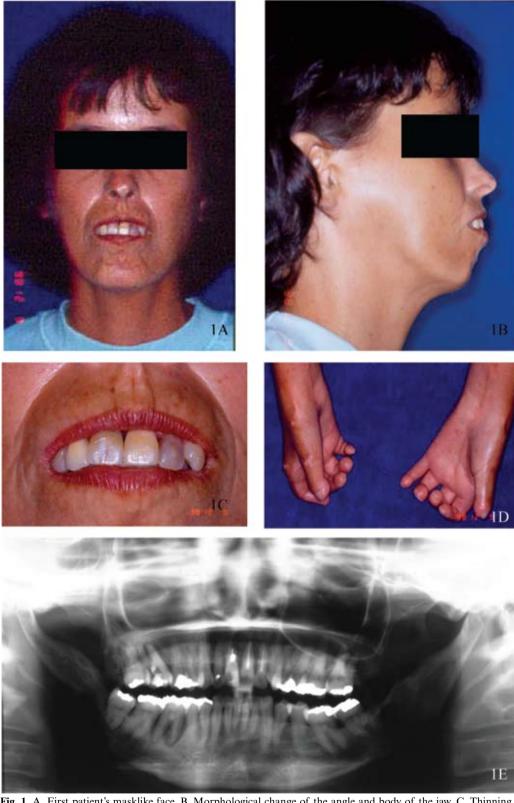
A. First patient's masklike face. B. Morphological change of the angle and body of the jaw. C. Thinning aspects of lips. D. Note that fingers are fixed in a clawlike position. E. Panoramic radiographic evaluation may shows a characteristic bilateral resorption of the angle and coronoid process.
